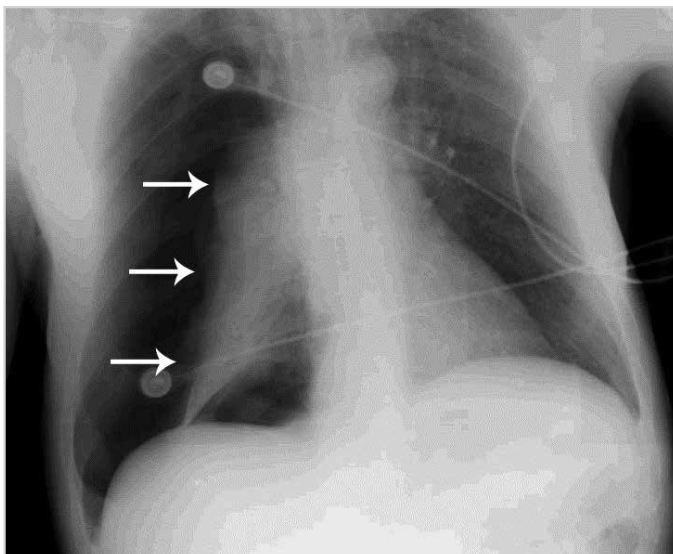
Anteroposterior radiograph showing right extensive pneumothorax with complete atelectasis
